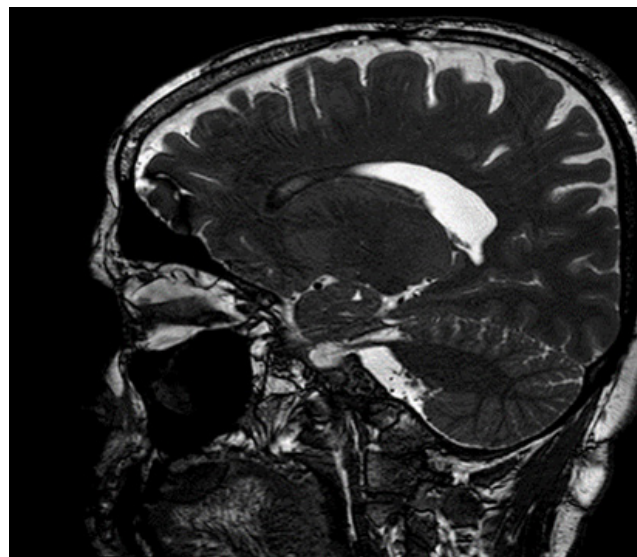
CSF Flow MRI imaging: Hyperdynamic CSF flow at the aqueductal level.
